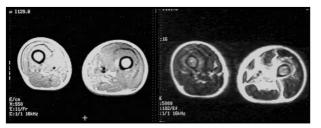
28 year old woman with left thigh pain Axial MR image T2 (TR/TE 5000/102) reveals increased SI in the medial aspect of the left thigh. Biopsy failed to demonstrate infection (sterile infarct).
